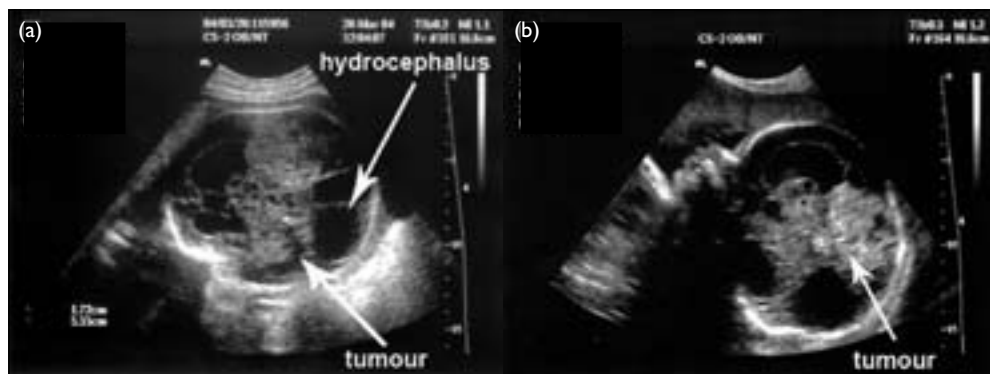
Obstetric ultrasound of the intracranial tumour at 28 weeks of gestation
